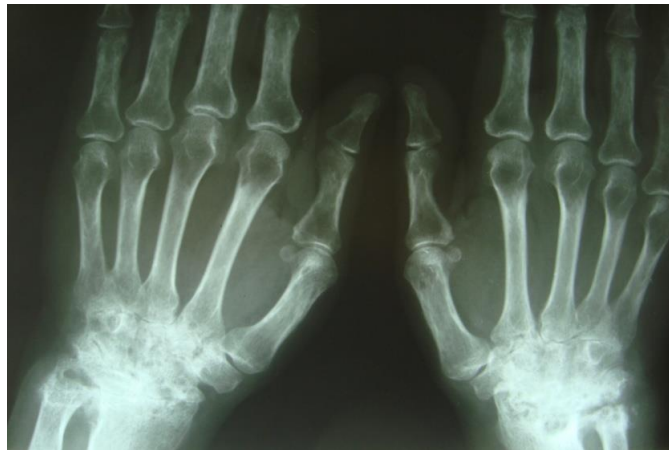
Radiography of the hands showing the African variant of rheumatoid arthritis with predominate wrist disease and sparing of the small joints of the hands.
